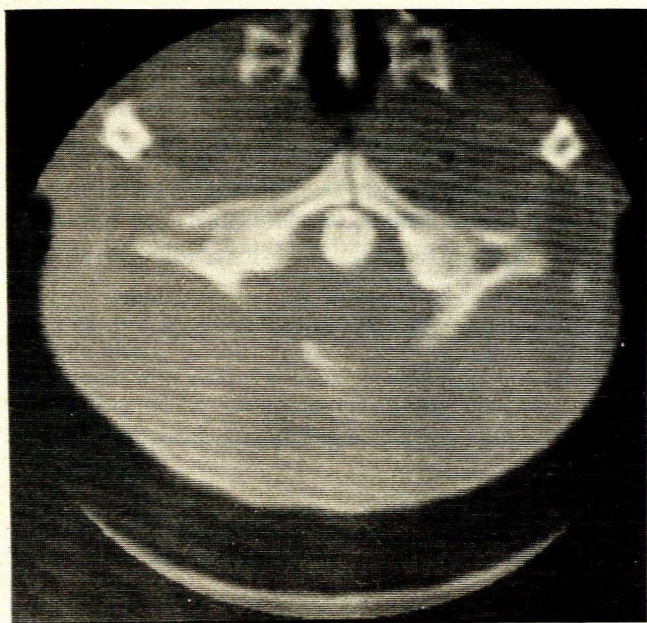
Whole-body CT scan demonstrating the anterior arch fracture. Note the sclerotic edges and the absence of 'mushrooming'.
